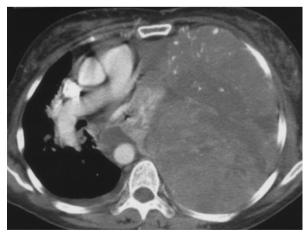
Computed tomographic scan disclosed a huge and heterogenous mass in the left pleural cavity with mediastinal compression.
